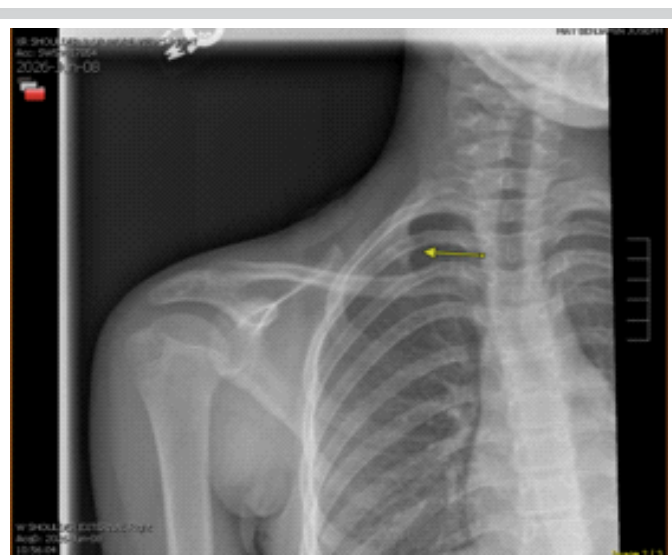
Follow-up right shoulder radiograph demonstrating complete healing of the right first rib fracture, with the previously seen fracture lucency no longer visible.
